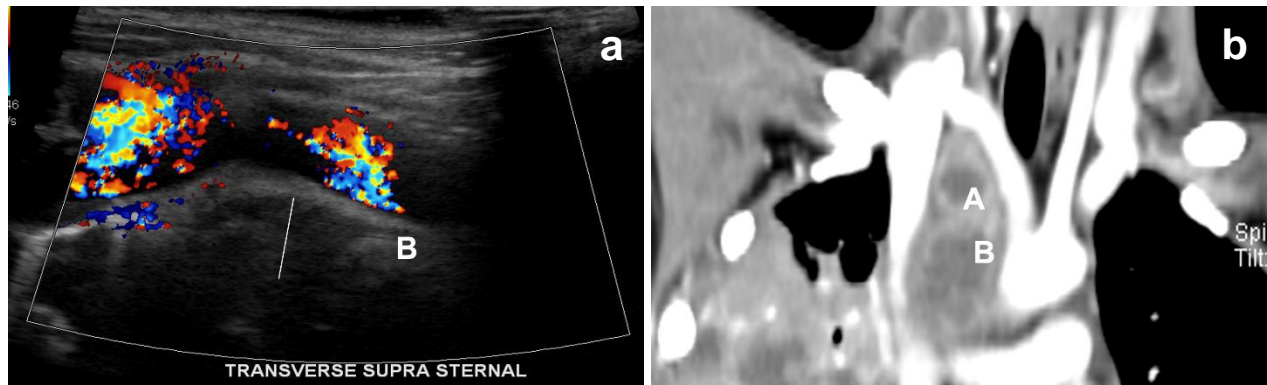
Predefined zones in the transverse suprasternal view in ultrasound (a) and computed tomography (b). An enlarged lymph node (white line behind the colored brachiocephalic veins) is noted in zones A & B, with corresponding coronal CT image in soft tissue window setting
